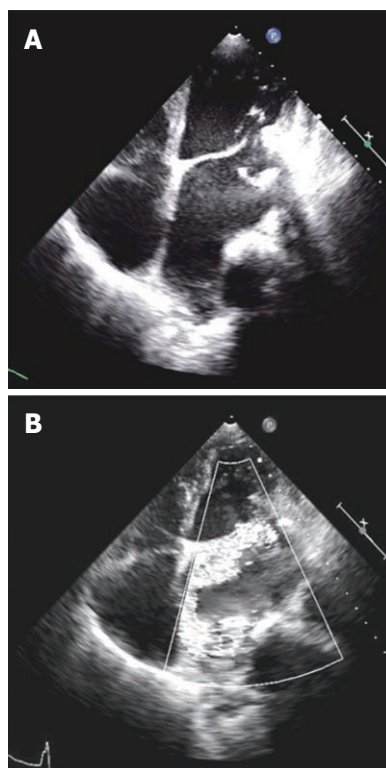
Echocardiography in apical 4 chamber view. A: Calcified, thickened and retracted posterior mitral leaflet with adjacent mitral annular ring calcification; B: Color Doppler showing severe mitral regurgitation.
